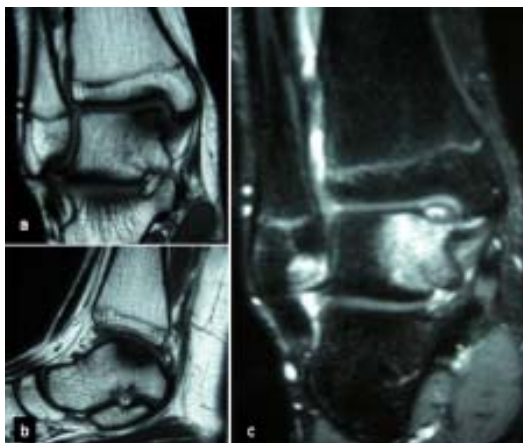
Magnetic resonance imaging (MRI) of the ankle joint. (a) The oblique coronal MRI demonstrating a lesion in the medial talar dome. (b) The sagittal MRI shows a thin fibrillated cartilage covering the osteochondral lesion in the medial aspect of the talar dome. (c) T-2 weighted oblique coronal MRI demonstrating high signal intensity of oedema surrounding the lesion consistent with grade 2a lesion.
